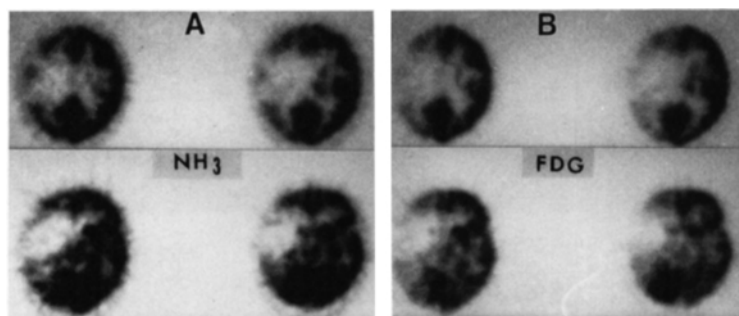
(A) $^{13}\text{NH}_3$ -ammonia and (B) ^{18}F FDG scans of patient with stroke involving right middle cerebral artery.
